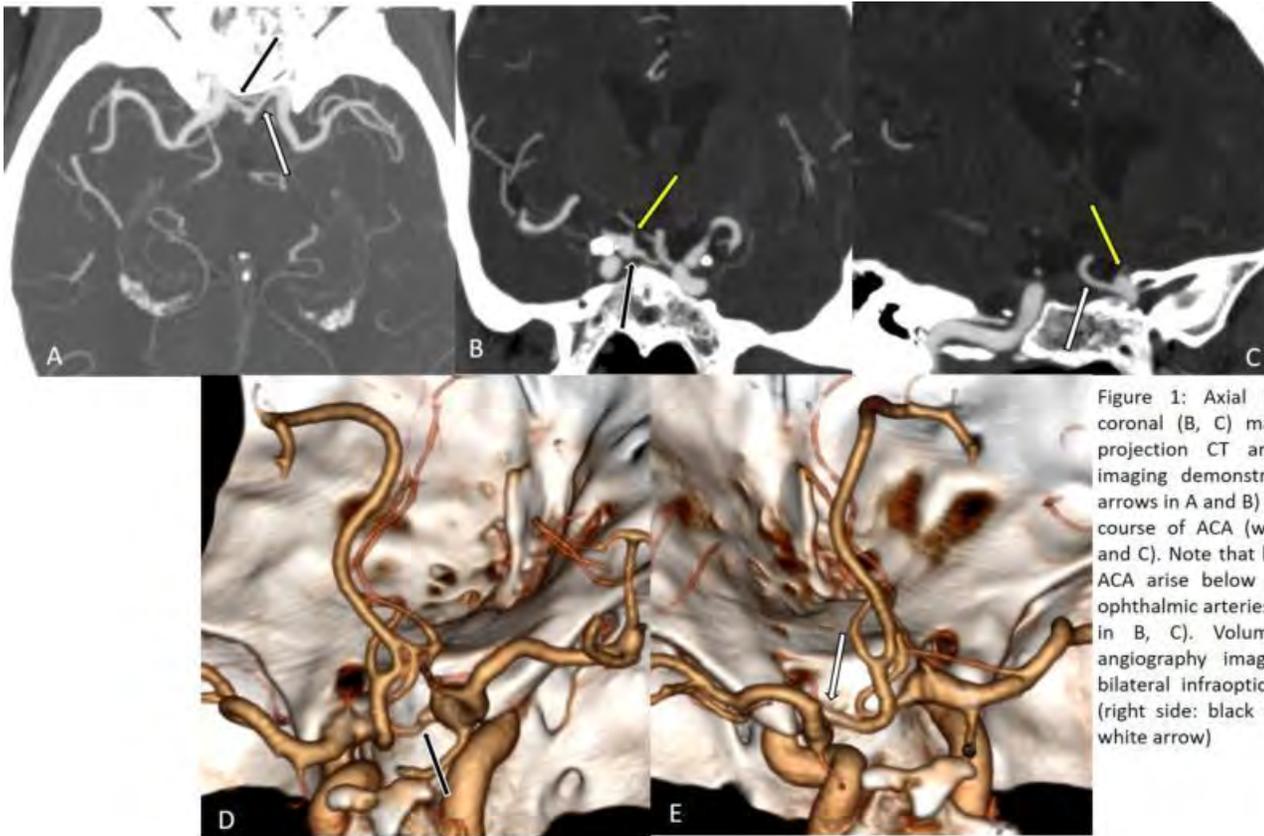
Axial (A) and oblique coronal (B, C) maximum intensity projection CT angiography (MIP) imaging demonstrates right (black arrows in A and B) and left infraoptic course of ACA (white arrows in A and C). Note that both the aberrant ACA arise below the level of the ophthalmic arteries (yellow arrows in B, C). Volume rendered CT angiography image (D, E) shows bilateral infraoptic course of ACA (right side: black arrow; left side: white arrow)
